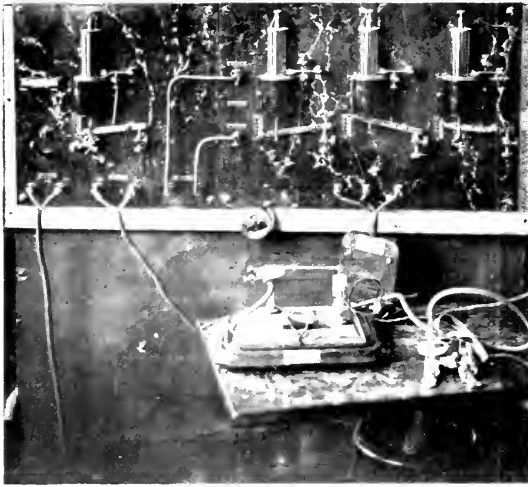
TIMER TO SET OFF THE X-RAY EXPOSURE IN RELATIONSHIP TO THE PULSE. Specially devised switch activated by the pulse seen in foreground.
